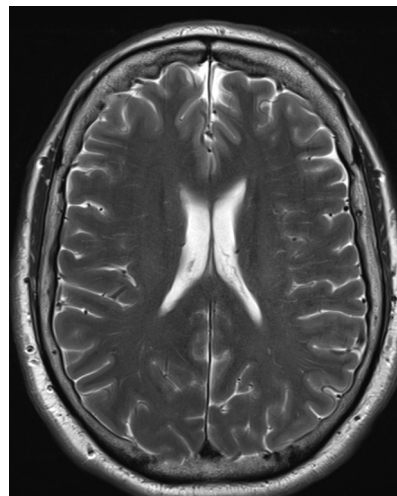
MRI head. An axial view of his MRI head.
